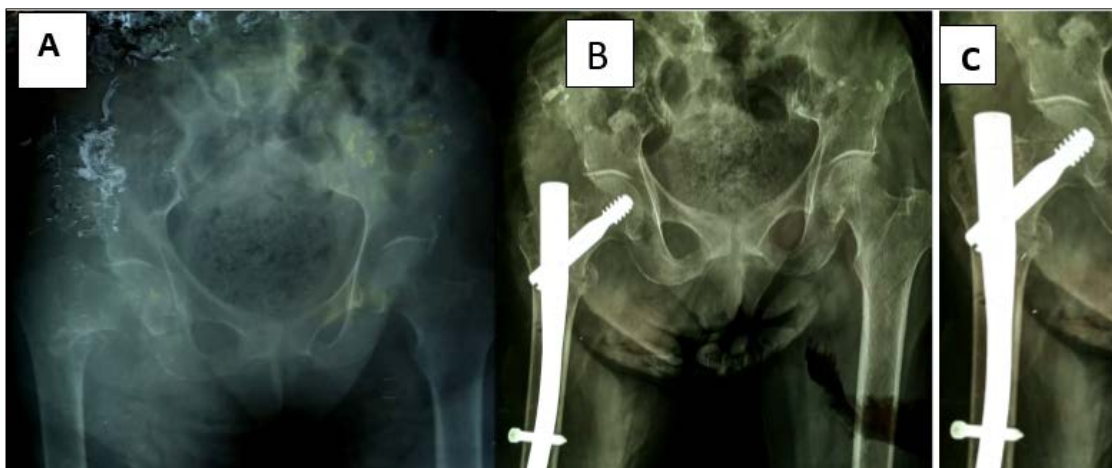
X-ray of the pelvis, side A, showing a consolidated right petrochanteric fracture
